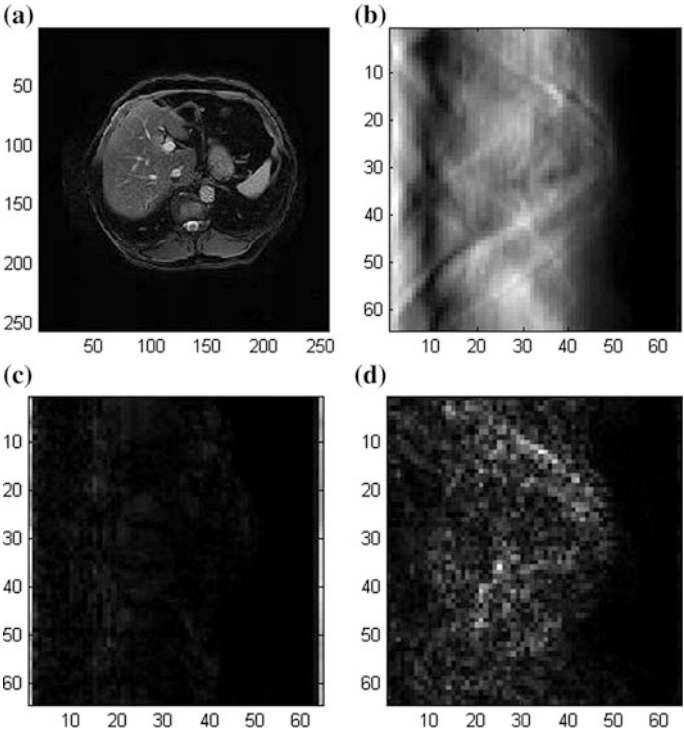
a A liver MR image, b–d 2nd level complex OrtRip-II coefficients for $d = 2$ (b: Approximation, c–d: 2 of 6 detail components)
